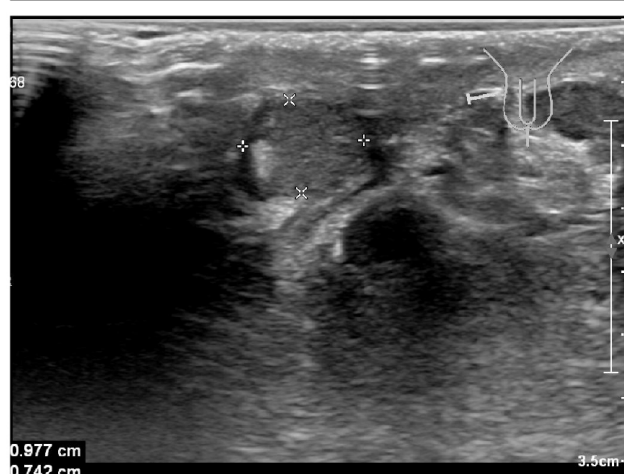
Testicular ultrasound report of the patient. Ultrasound examination showed bilateral testicular atrophy.
